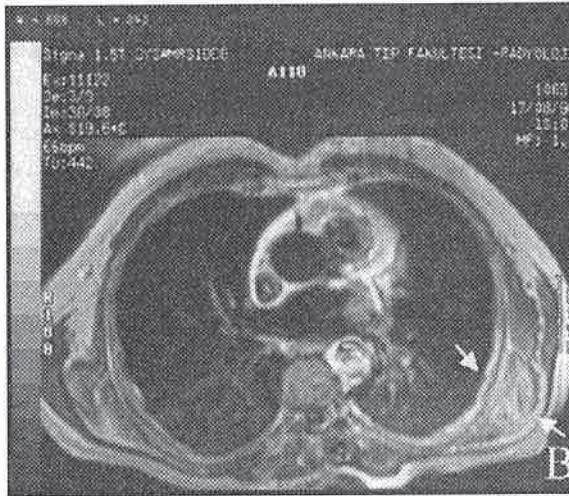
The mass demonstrated mild enhancement after gadopentate dimeglumine administration on T1-weighted axial image.
